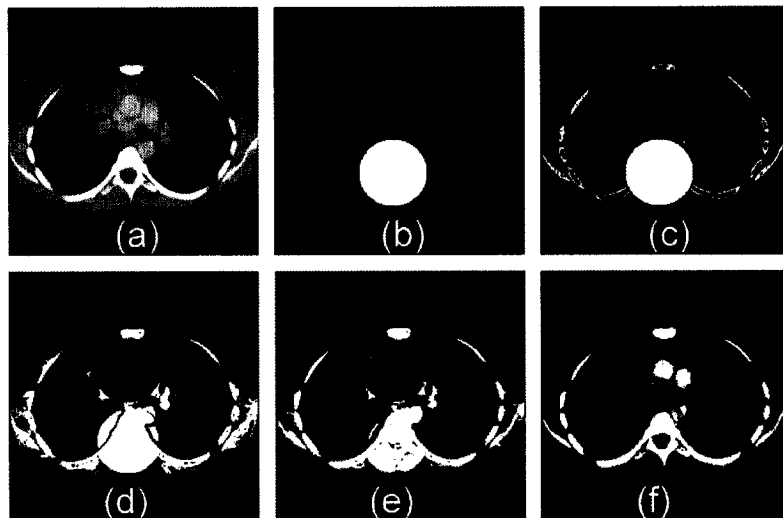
Experimental results on CT scans. (a) Iteration 0. (b) Iteration 20. (c) Iteration 50. (d) Iteration 100.(e) Iteration 125. (f) Iteration 150.
